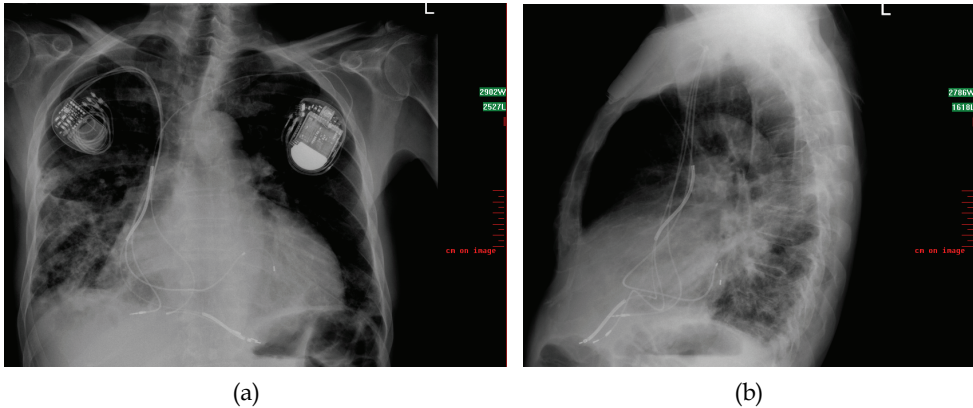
a and b. Chest x-ray PA and lateral: unfavourable positioning of ventricular electrodes to avoid oversensing: parallel position, very small distance < 1 cm. (Pacemaker/CRT-P: InSync, Medtronic. ICD: Lumax 300 VR-T, Biotronik)
